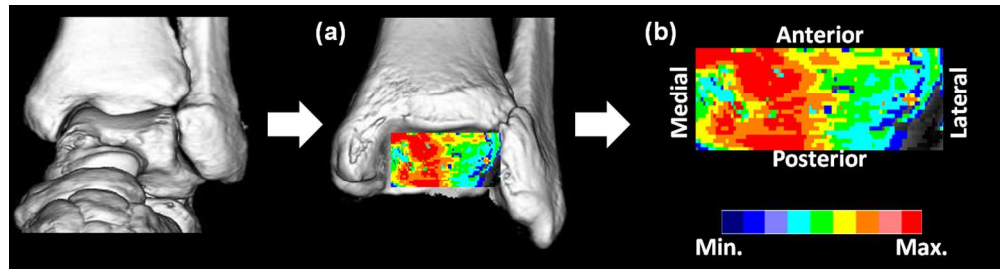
Results of computed tomography (CT)-osteabsorptiometry.
